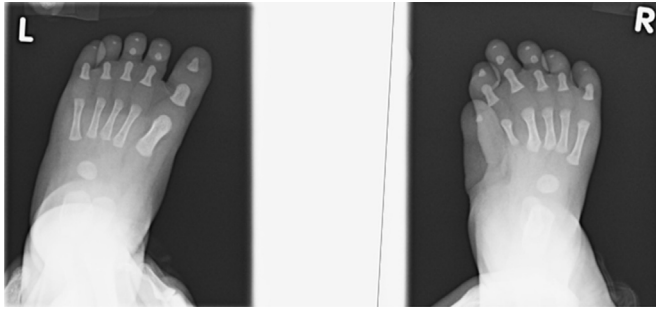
X-ray at 6 months.
